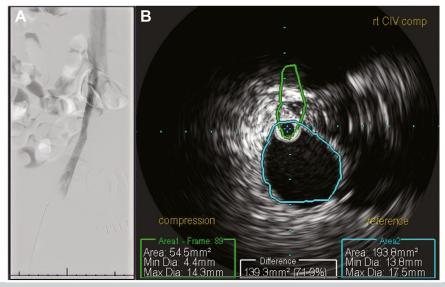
(A) Venogram from the right popliteal vein reveals right common iliac vein (*CIV*) stenosis. (B) Intravascular ultrasound (*IVUS*) image of the compressed segment of the right CIV (*green*) superimposed over the normal native right CIV (*blue*).
